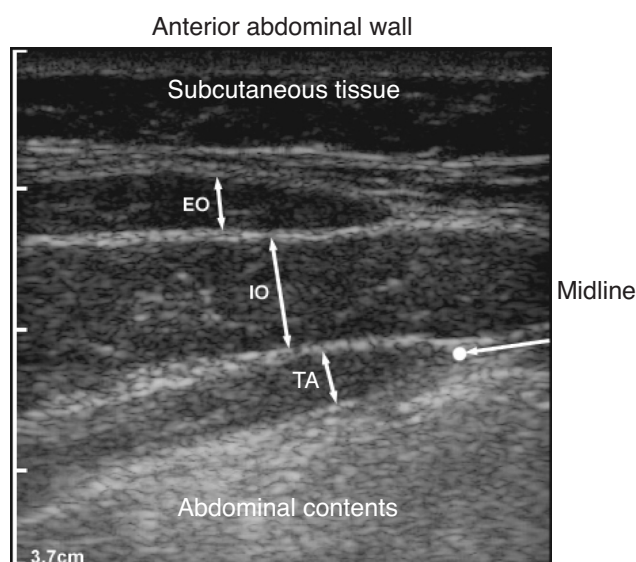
A transverse view of an ultrasound image of the same (as in Figure 1) subject's contracted transversus abdominis (TA) muscle (the ultrasound head was not moved after imaging Figure 1). The single arrow and white filled circle indicate the medial border of the TA muscle that has moved laterally compared to the medial border of the TA muscle in Figure 1. Also note that the thickness of the TA muscle and, to a lesser extent, the internal oblique (IO) muscle has increased with the subject's voluntary contraction, whereas the external oblique (EO) muscle has not changed thickness compared to the EO muscle in Figure 1. The scale on the left side of the ultrasound image indicates the depth.
